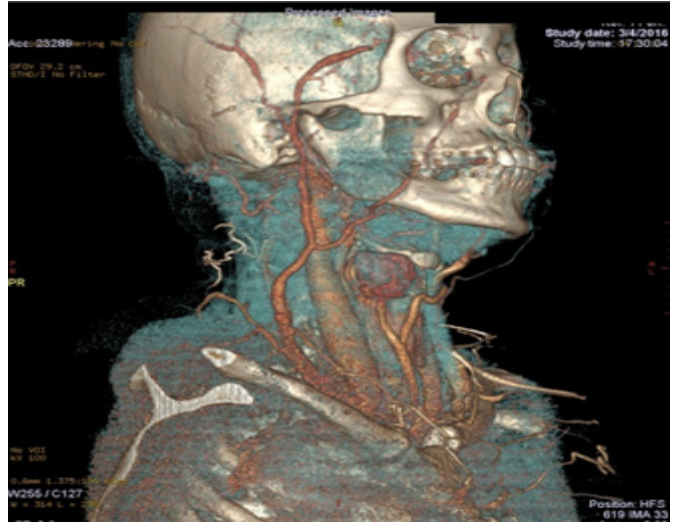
CT angiogram of neck showed aneurysmal swelling of right anterior jugular vein.
